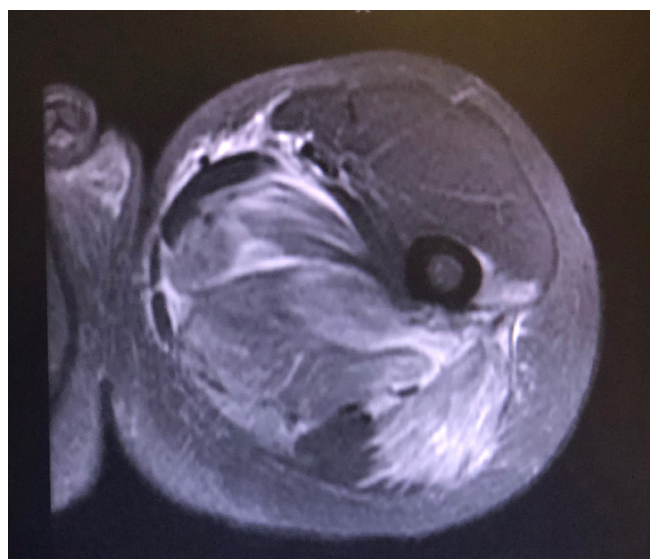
Axial STIR sequence MRI of proximal left thigh showing inter-fascial edema in posterior and medial compartments.
